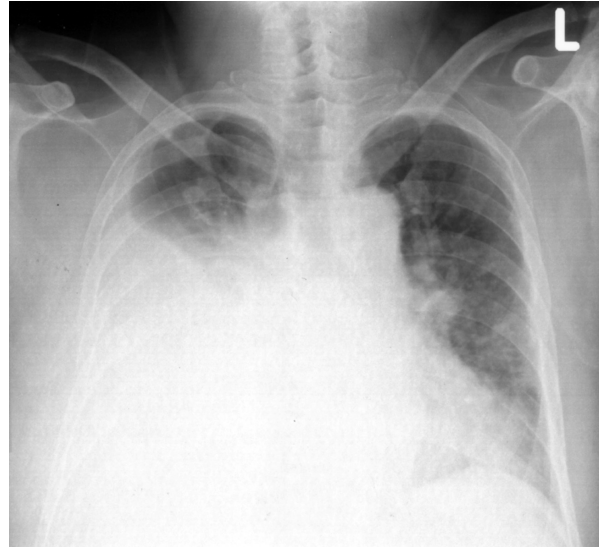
A standing chest radiograph showing massive pleural effusion at the right side.
